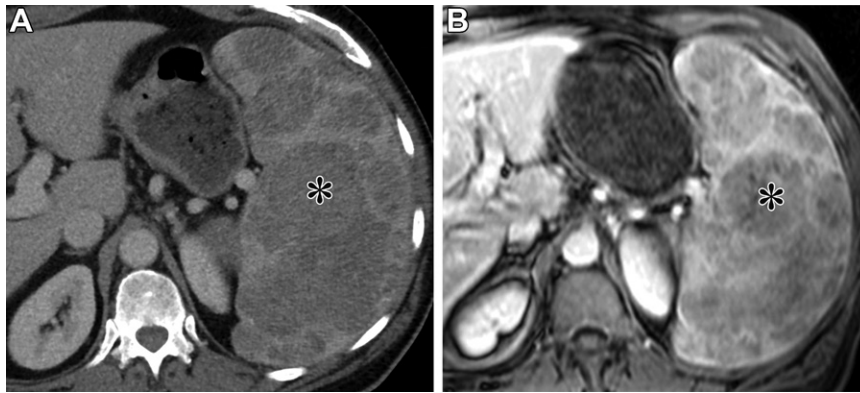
LCA in a 65-year-old man with chronic thrombocytopenia. Axial contrast-enhanced CT (A) and T1-weighted (B) images in the portal venous phase show splenomegaly with multiple hypoenhancing lesions (*).
